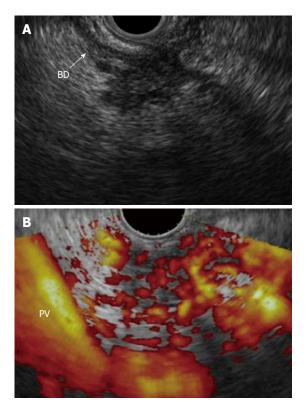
Focal chronic pancreatitis. A: EUS shows a mass with an irregular and inhomogeneous echo pattern at the head of the pancreas; B: Contrastenhanced power Doppler EUS shows an isovascular nodule compared with the surrounding pancreatic tissue. BD: Bile duct; PV: Portal vein.
